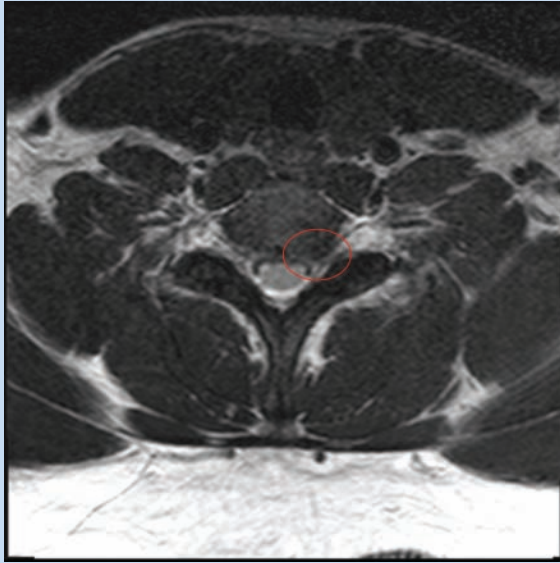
MRI of the cervical spine C7-T1 level showing small left paracentral disc protrusion (circle) without significant central or neural foraminal narrowing.
